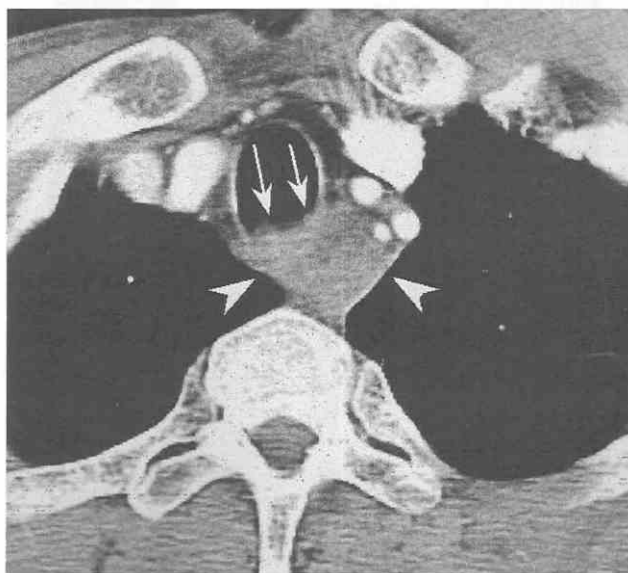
Esophageal cancer with tracheal invasion. CT scan shows circumferential wall thickening of the proximal esophagus (arrowheads), which shows irregular interface with the posterior wall of the trachea (arrows), indicating direct extension into the lumen.
